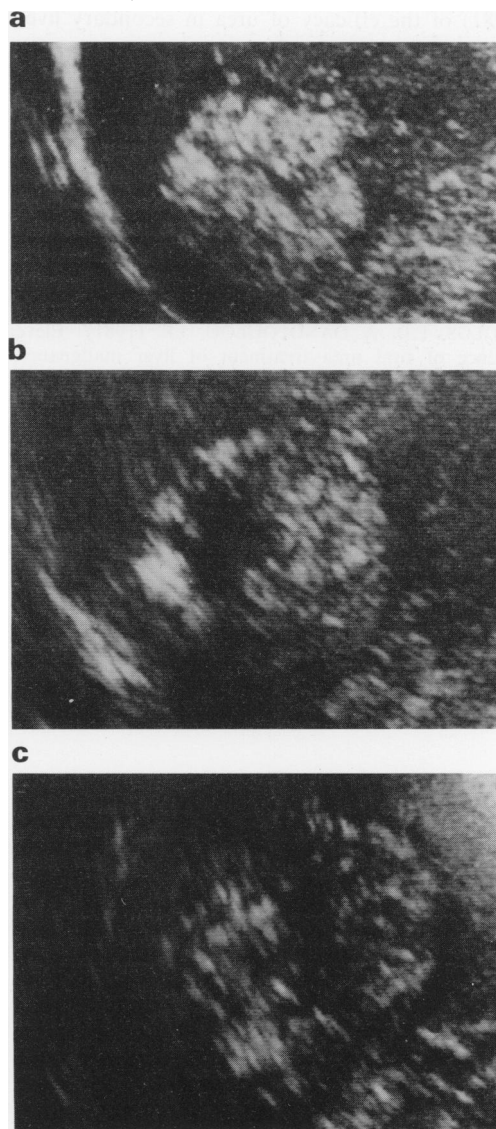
Liver ultrasound scans demonstrating progression of an echogenic colon carcinoma metastasis on urea treatment: (a) start of urea: 6 cm diameter; (b) 11 months later: 8 cm diameter; (c) 22 months later: 10 cm diameter. (All images to same scale.)
